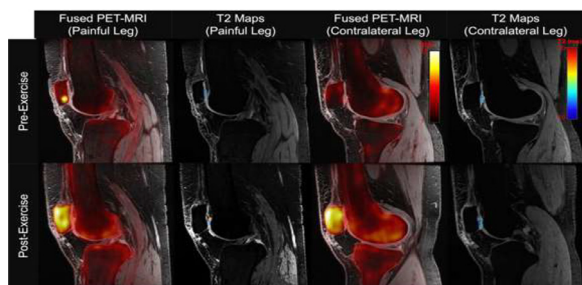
Representative images from a 53-year-old subject with unilateral knee pain are shown above. Fusion PET-MR images are shown for the painful leg (column 1) and the contralateral leg (column 3) along with combined qDESS and T2 maps for the painful leg (column 2) and the contralateral leg (column 4). The top panel showcases the pre-exercise images while the bottom panel shows the post-exercise images.
